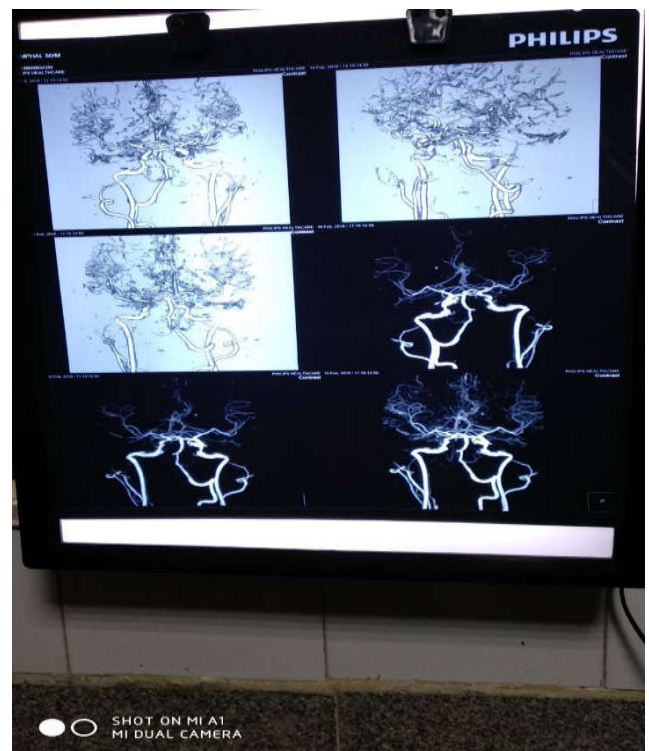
CT angiography showing hypoplastic left vertebral artery with stenotic or occluded V3 & V4 segment were seen on film
